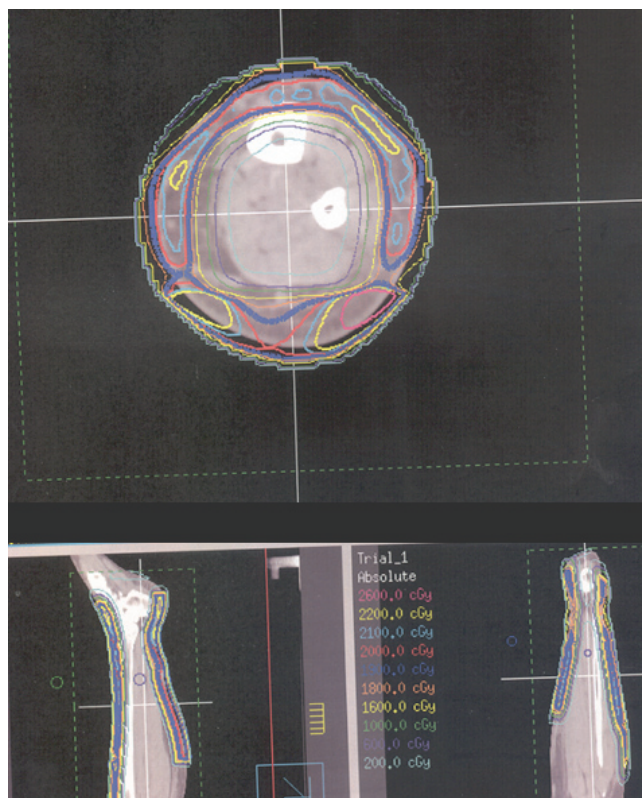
Axial planning (computed tomography) image depicting electron dosimetry.
